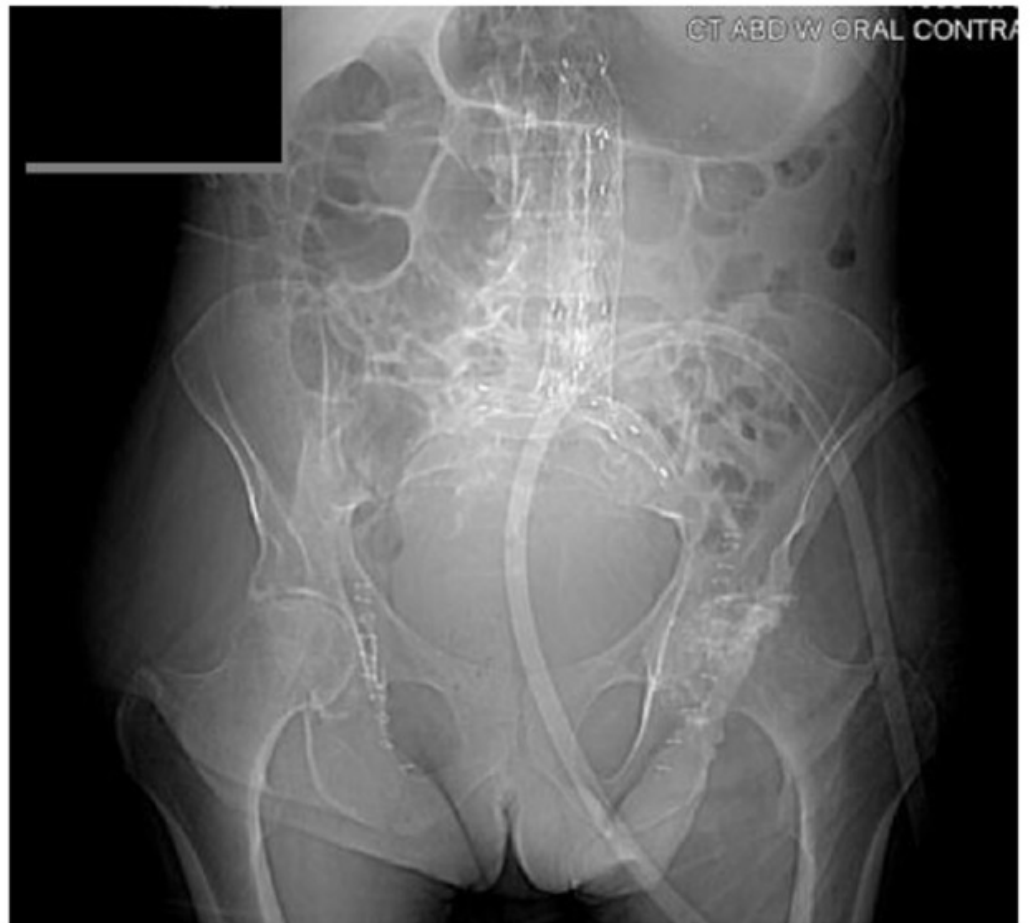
Plain CT scout film showing endovascular AAA stent graft in place
